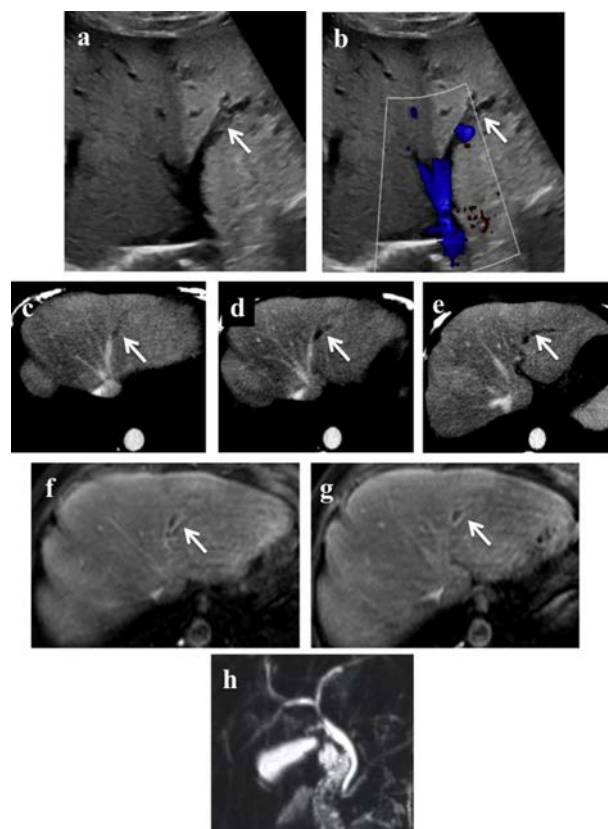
Axial ultrasound scans without (a) and with color Doppler (b) demonstrate echogenic material (white arrows) inside the left supra-hepatic vein compatible with partial thrombosis. Axial post-contrast scans of computed tomography (c, d, e) and magnetic resonance imaging (f, g) confirm the finding of thrombosis of the left supra-hepatic vein (white arrows). Magnetic resonance cholangiography shows a regular anatomical aspect of the bile ducts, gallbladder, and pancreatic duct (h).
